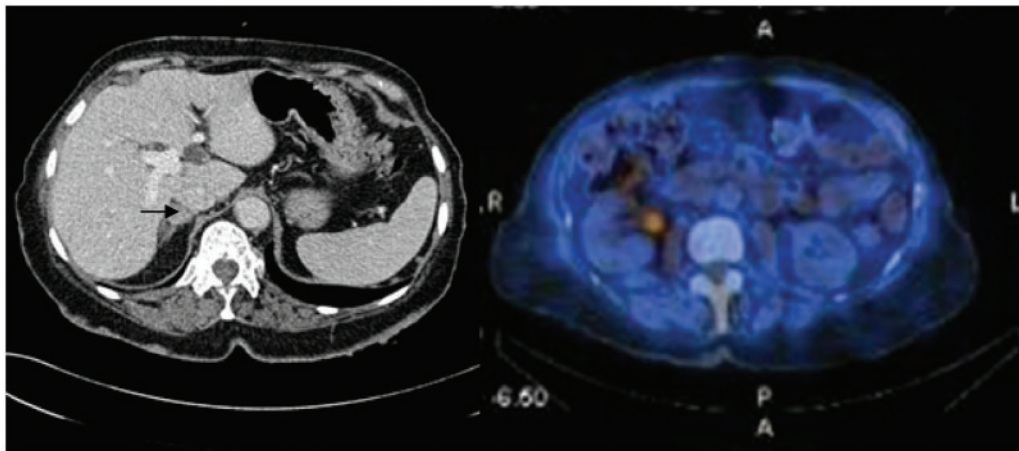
Right adrenal nodule (arrow) seen on CT scan (left image) and ^{123}I -mIBG scintigraphy showing avid uptake in the right adrenal nodule.
